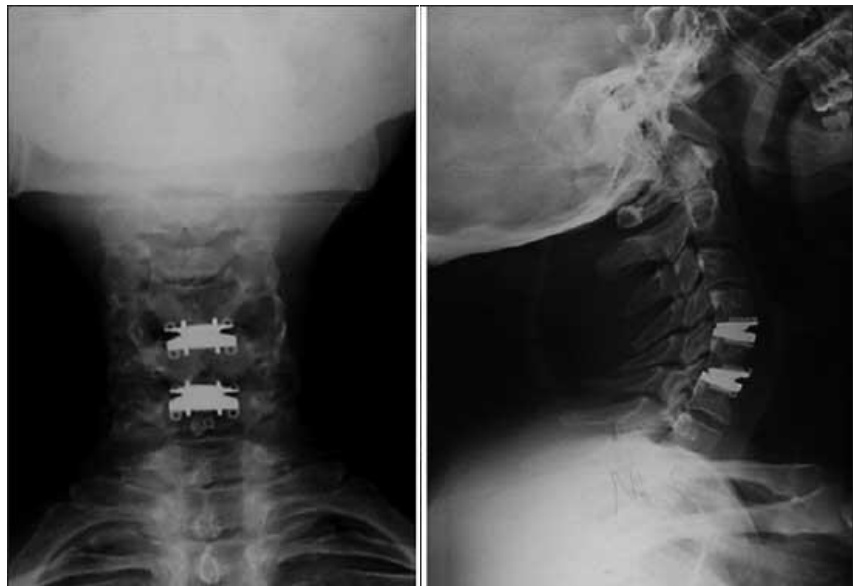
Radiograph of adjacent articulated cervical replacement disks in a human subject while maintaining range of motion. Adapted from Cincu 2014.
